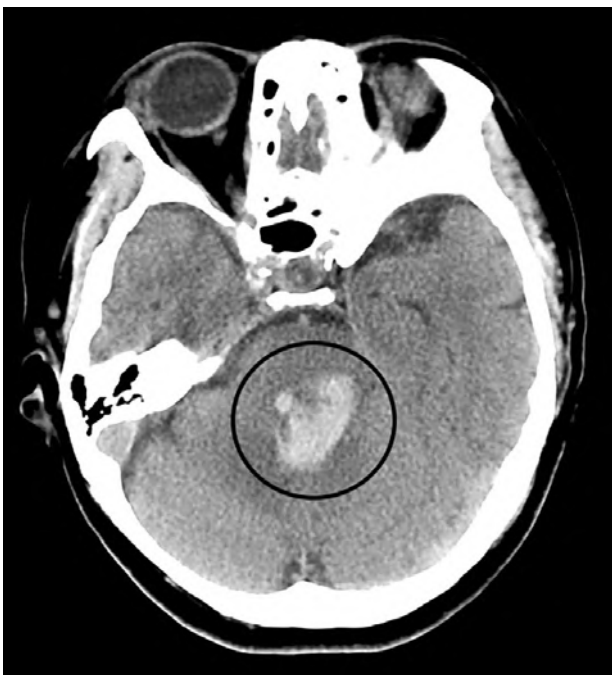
Non-contrast computed tomography brain demonstrating pontine hemorrhage with fourth ventricle involvement (circle).
